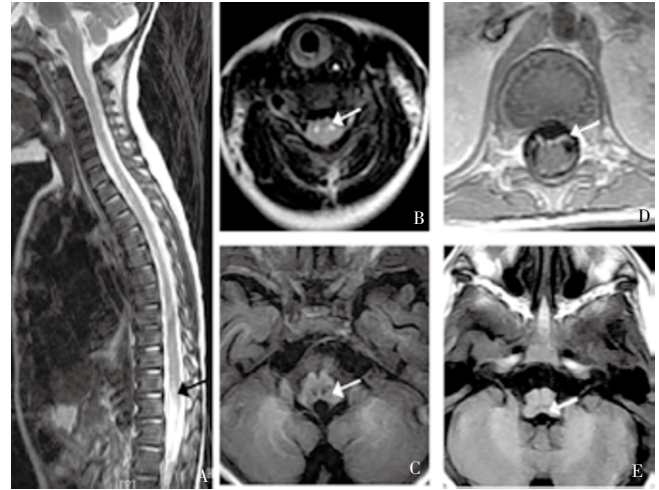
Changes of MRI of case No.1 before and after treatment.
